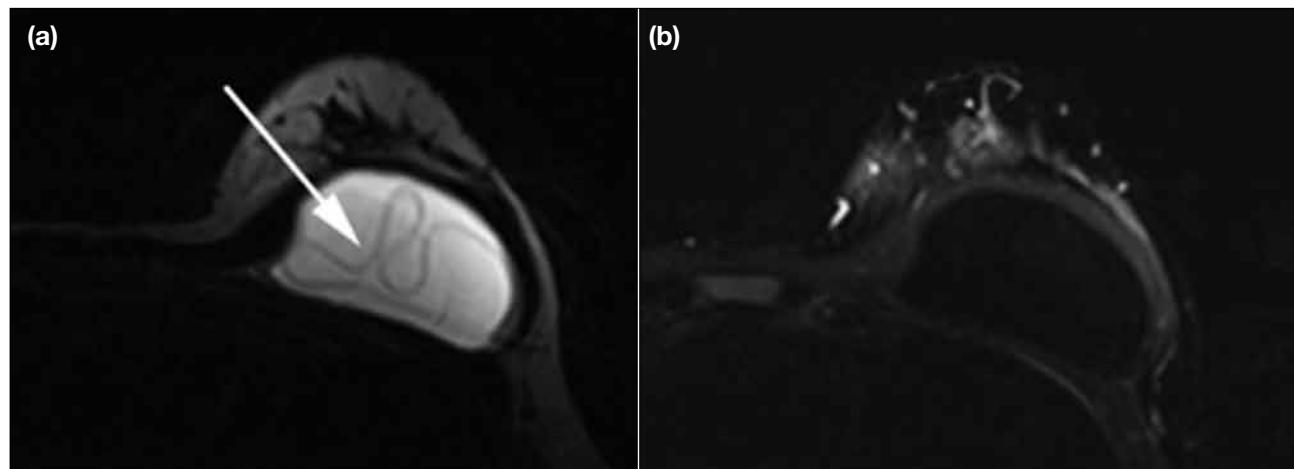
Magnetic resonance imaging of a 41-year-old woman with bilateral breast implants showing left implant rupture: (a) axial water-suppression and (b) axial silicone-suppression images. Intra-capsular rupture of a single lumen silicone filled implant with presence of 'linguine sign' (arrow) in the left breast.
